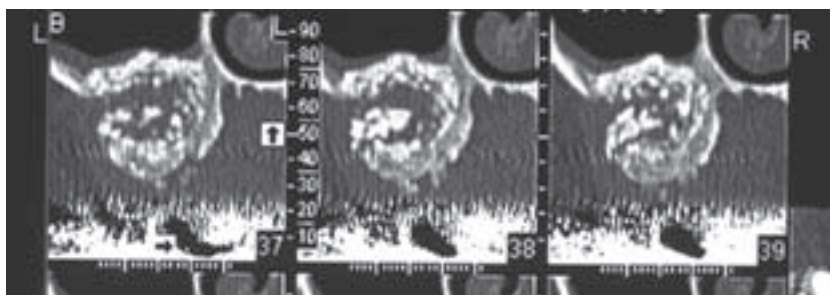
Cross-sectional CT view showing a buccal drainage tract.
